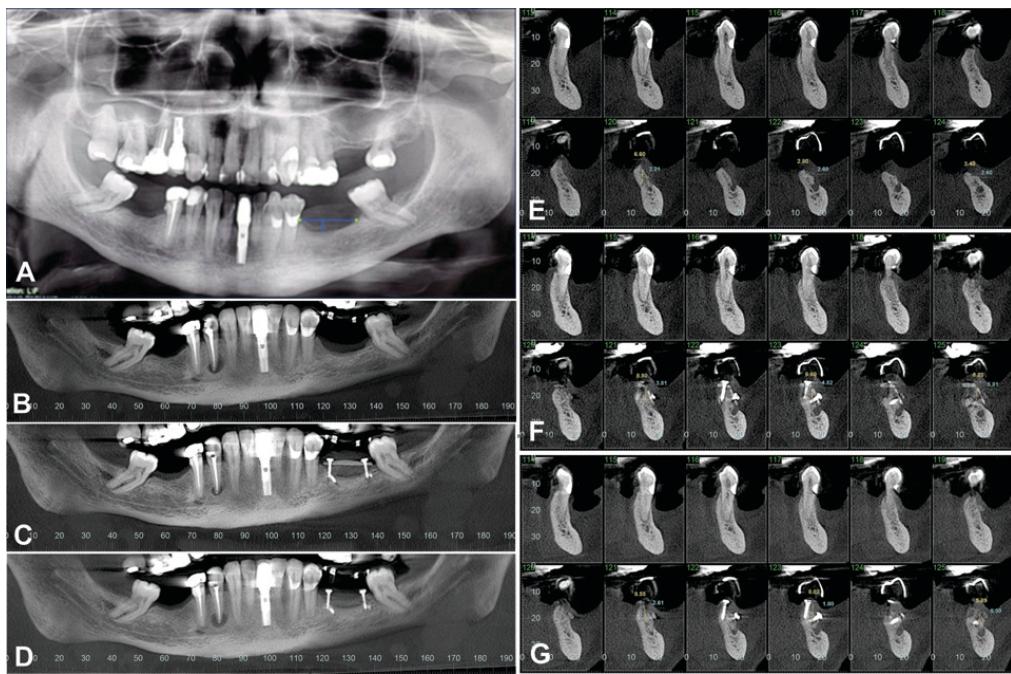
Initial panoramic radiography (A), Initial cone bean CT (CBCT) (B and E), CBCT with 14 days after surgery (C and F), CBCT with 4 months after surgery (D).
